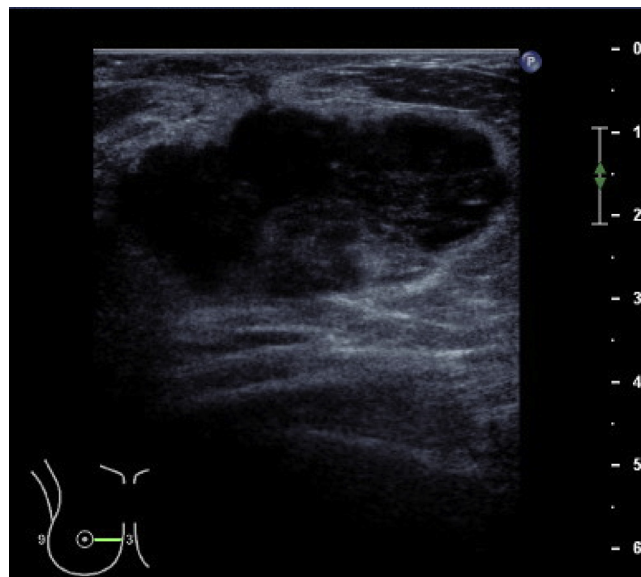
Breast ultrasonography. Breast ultrasonography shows a low-echoic tumor measuring 51 mm in diameter with irregular margins and a heterogeneous internal echo pattern in the AB area of the right breast.
